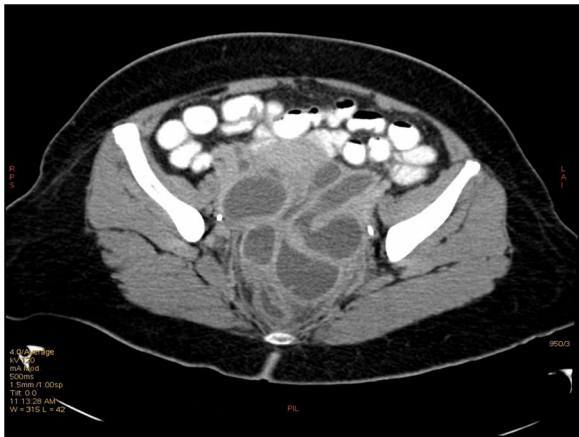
Abdominal CT showing tubo-ovarian abscesses.
